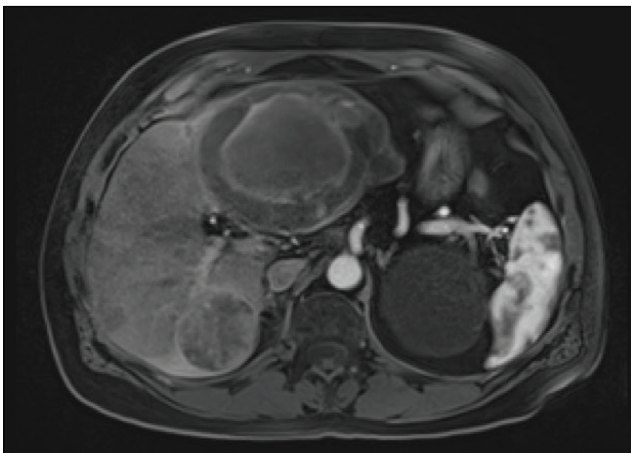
MRI demonstrated multiple lesions throughout the noncirrhotic liver with an enlarging solitary lesion in segment 5.
